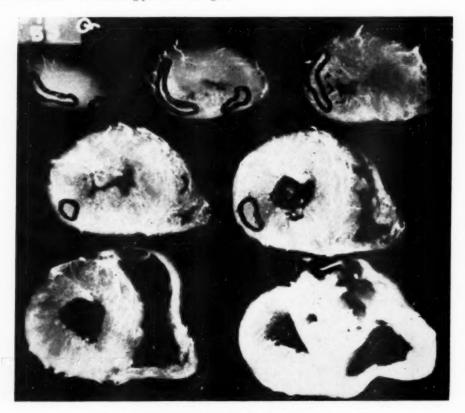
Roentgenogram of the injected heart in Case 157.
